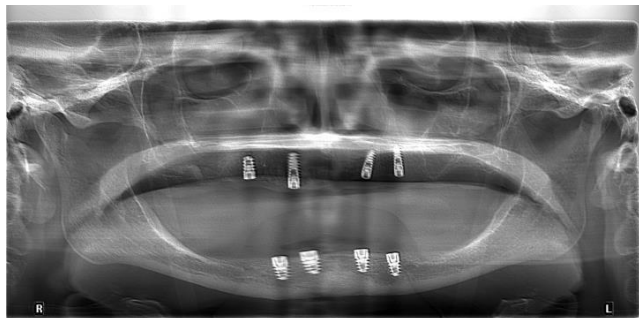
Postoperative CT after implant placement
